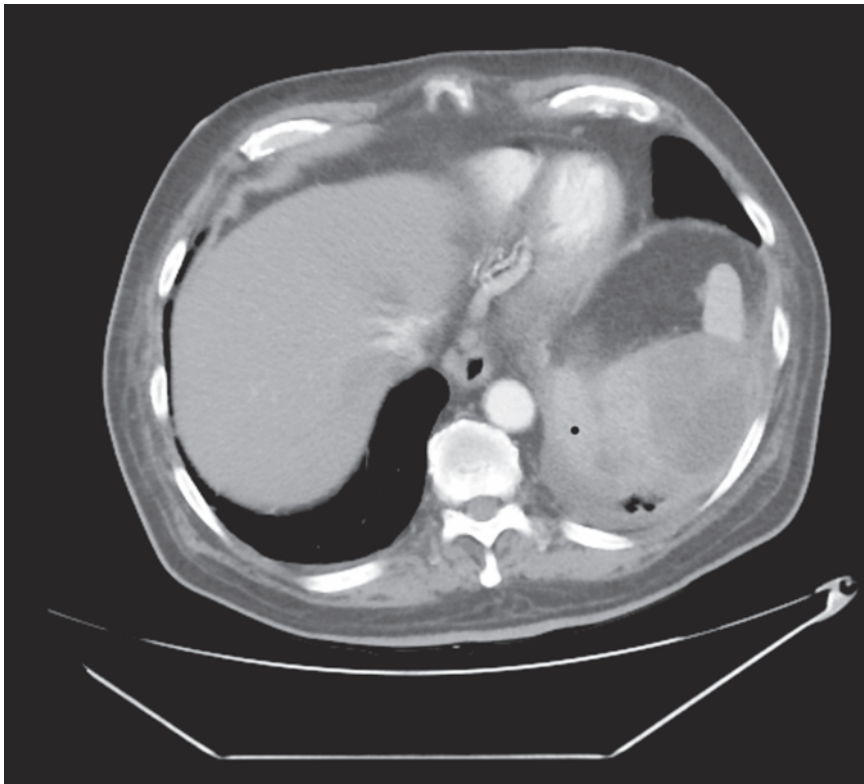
Multiple splenic hypodensities seen on computed tomography scan.
